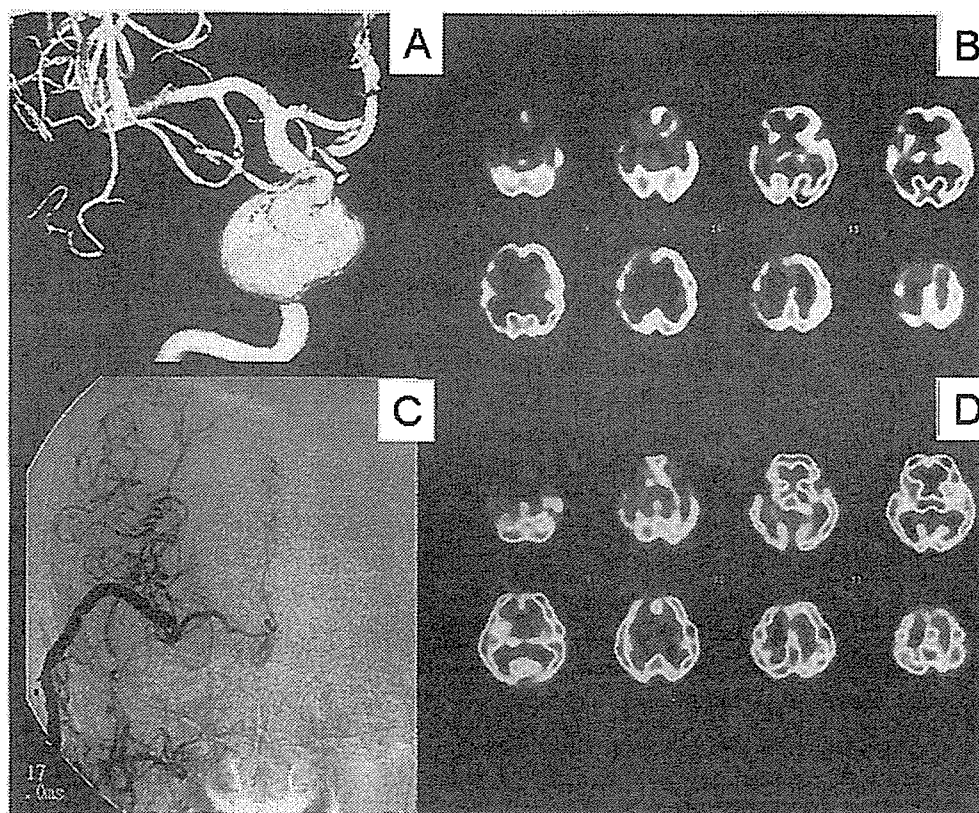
A 60-year-old woman who complained of diplopia due to right sixth cranial nerve palsy. A: A 3-dimensional digital subtraction angiography (3DDSA) showing a giant right ICA aneurysm at the cavernous portion. B: An ECD SPECT during BTO of right ICA showing marked flow reduction in the right (left of the figure) cerebral hemisphere (residual flow < 70% of the contralateral region). C: An angiography after surgery of external carotid-right middle cerebral artery bypass using saphenous vein graft and ligation of right ICA at the neck. The right intracranial carotid system is opacified through the vein graft and the aneurysm is not seen. D: An ^{123}I -isopropyl-p-iodoamphetamine (IMP) SPECT obtained next day of the surgery showing sufficient flow in the right cerebral hemisphere.
